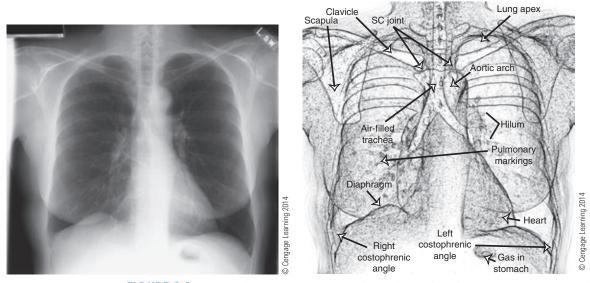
A normal posterior-anterior (PA) chest radiograph and corresponding anatomical structures.
